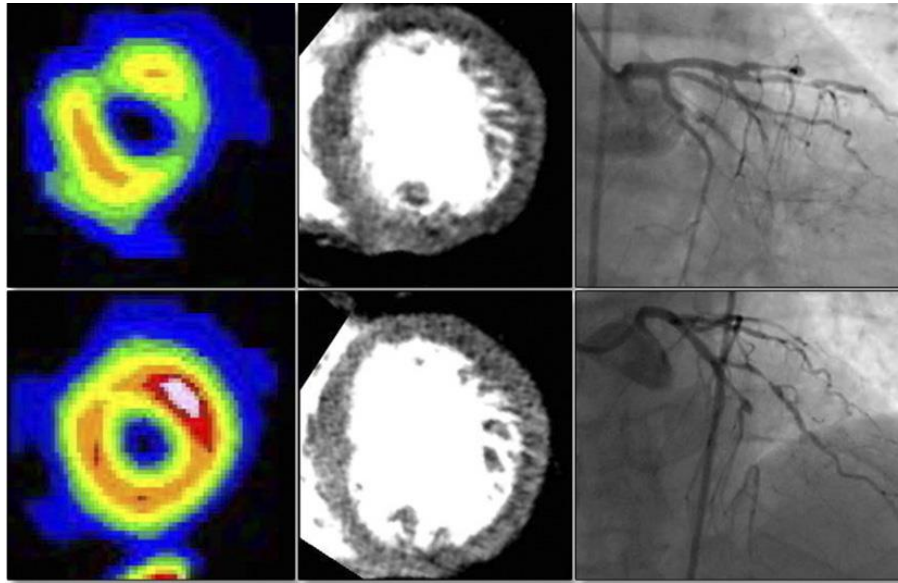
Comparison of SPECT perfusion (left), CT perfusion (center), and invasive coronary angiography (right) in a 55 year-old man in stress (top) and rest (bottom). The perfusion defects detected by CT and SPECT are related to the stenosis in the left circumflex at stress (top, right) and occlusion in the LAD at rest (right, bottom). Reprinted with permission from [38].
